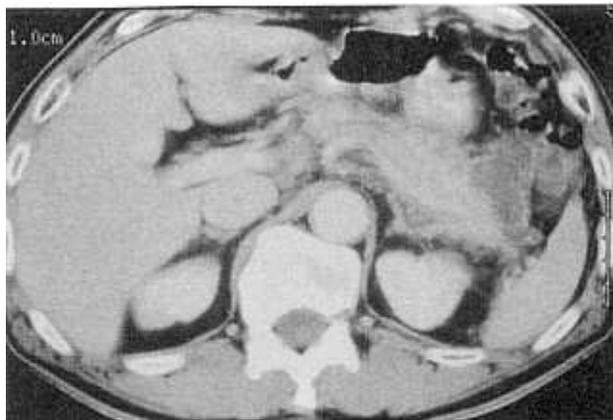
An abdominal computed tomography on the second admission. The main pancreatic duct is slightly dilated and peripancreatic infiltration and fluid collections are seen.
